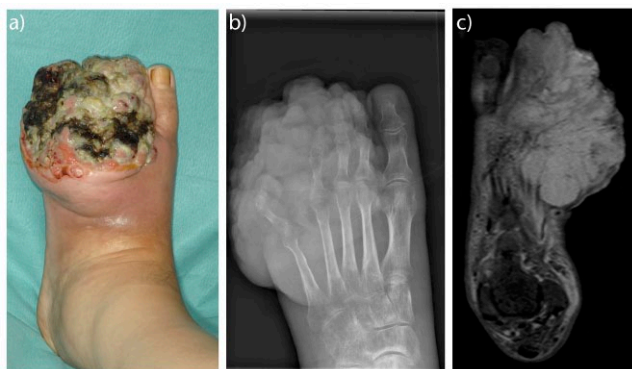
Ulcerating, partially-necrotic tumour on the dorsum of the left foot of a 53-year-old male patient (a). Radiograph shows displacement of the 4th and 5th digit by the mass (b). MRI reveals the actual extent of the tumour, later confirmed as high-grade synovial sarcoma (c).
